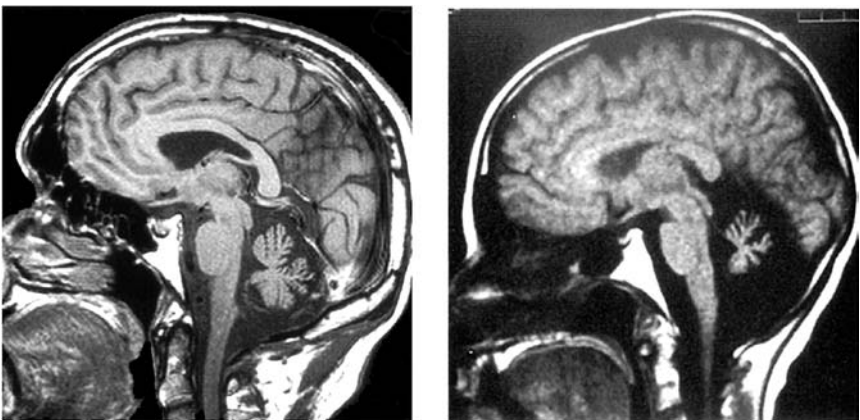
Ongoing Purkinje cell death leads to loss of cerebellar volume in AT. Left panel: CT image from a normal child. Right panel: CT image from an AT homozygote.
